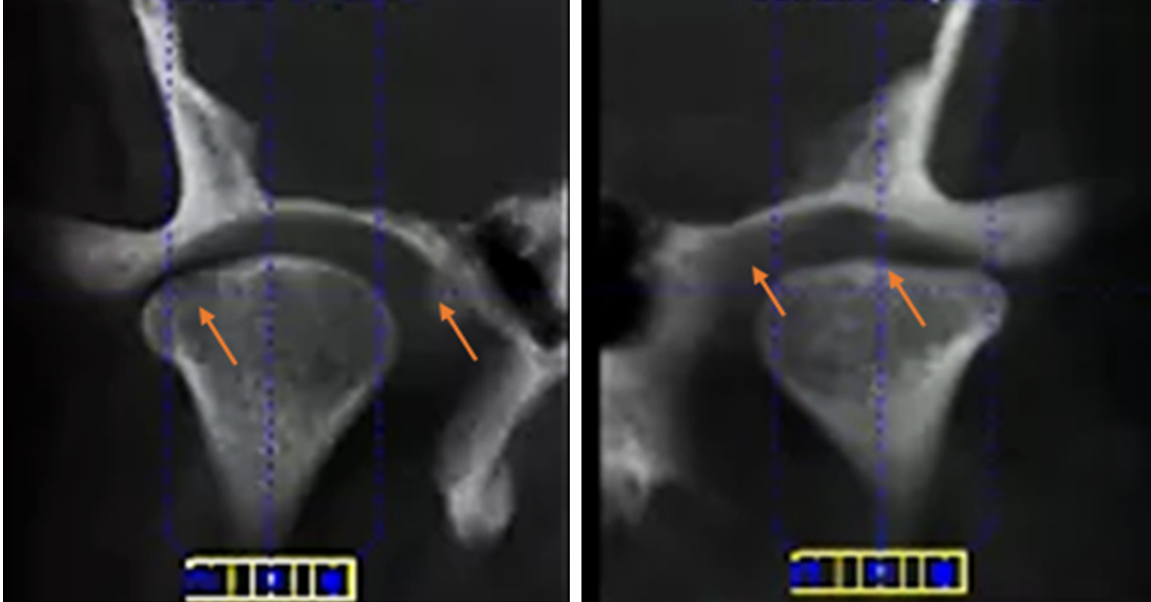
CT images of Female 48 years old. Left hand side: right condyle. Right hand side: left condyle. Observe the erosion in both temporalis. Bone loss in cortical bone on the right side, osteophytes on the right temporal. The left condyle is flattened and with temporal erosion.
